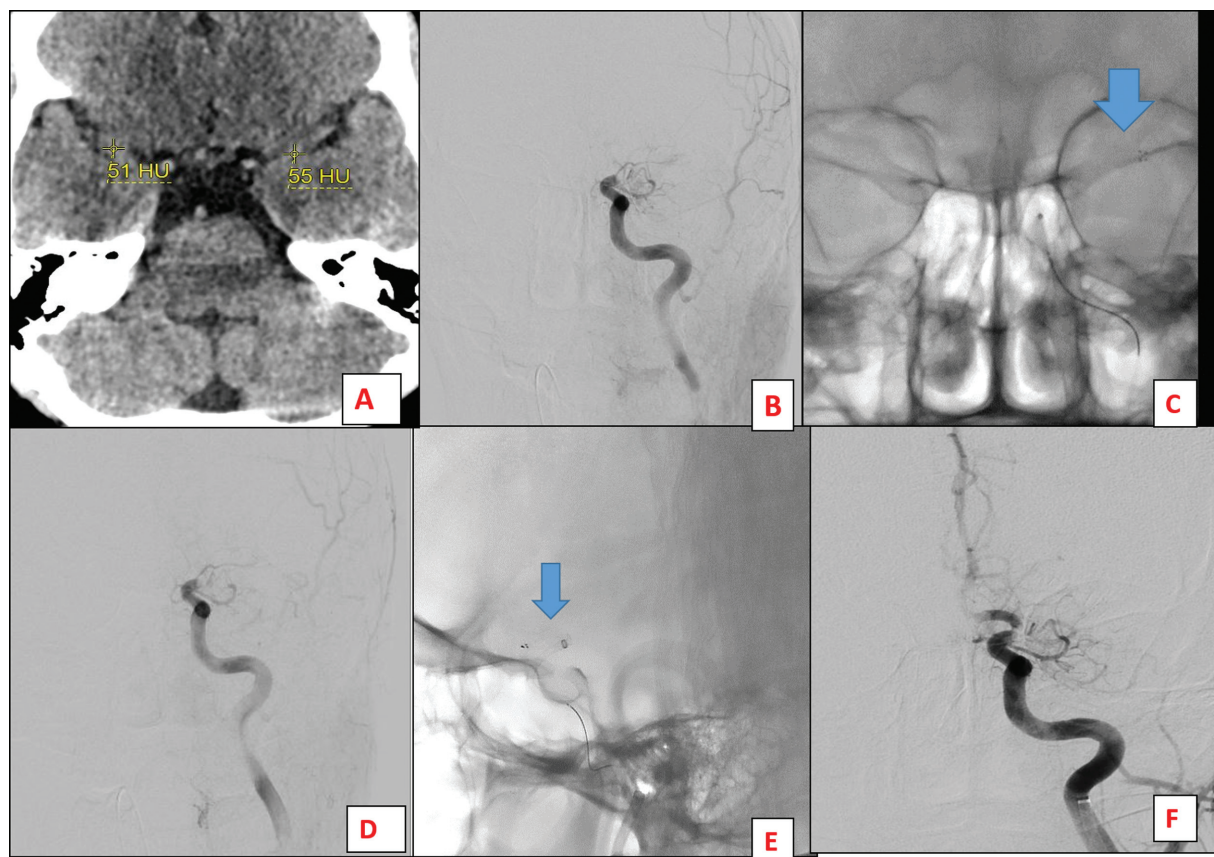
A known case of rheumatic heart disease (RHD), post-mitral valve replacement (MVR), and post-stuck valve thrombolysis, presented with sudden onset right-sided weakness persisting for 1 hour. On examination, National Institutes of Health Stroke Scale (NIHSS) was 20. (A) Noncontrast computed tomography (NCCT) shows similar density or no hyperdense sign in left middle cerebral artery (MCA). (B) Anterior-posterior (AP) view of left internal carotid artery (ICA) digital subtraction angiography (DSA) run shows cutoff at left terminal ICA level. (C) The stent retriever was deployed in the left MCA and terminal ICA (as shown by the thick blue arrow). (D) After two passes of stent retriever recanalization was not established, T occlusion persisted (modified thrombolysis in cerebral ischemia [mTICI] = 0). (E) Lateral view shows stent and aspiration catheter assembly (Solumbra) as shown by blue arrow. (F) AP view of the left ICA run after 2 Solumbra technique attempts shows persistent MCA occlusion (mTICI = 0). No recanalization happened after 4 retrieval attempts.
